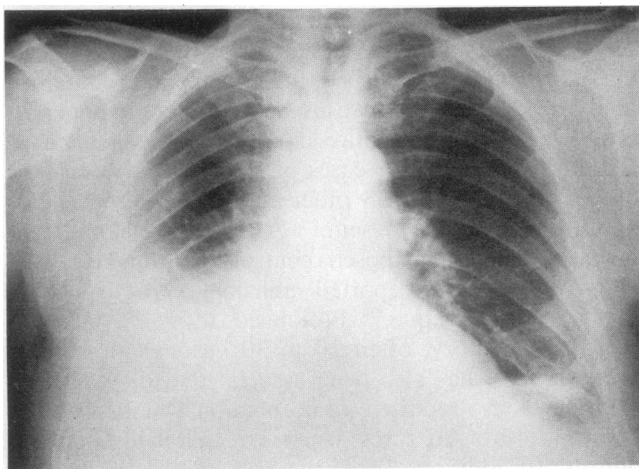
X-ray film of the chest showing right pleural effusion and diffuse malignant mesothelioma in a 63-year-old brickmaker who made bricks containing asbestos from 1942 to 1955.
